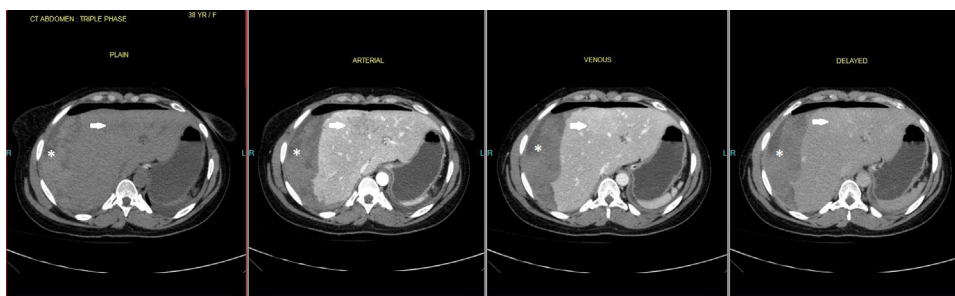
CT scan abdomen post laparotomy.
